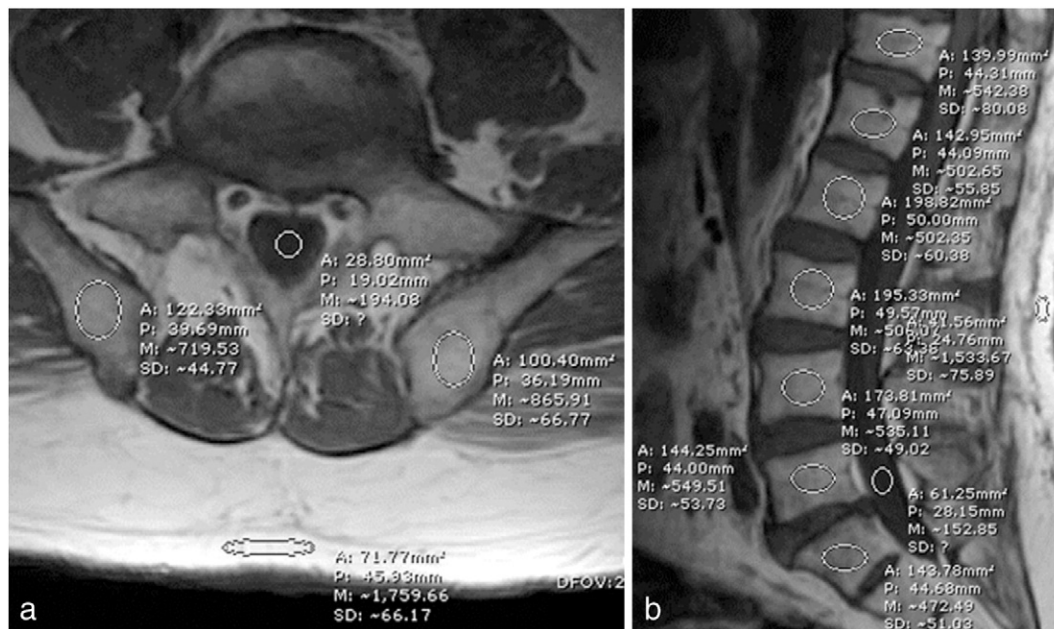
A 56-year-old man with lymphoma without marrow involvement. Axial T1W MR image at the L5/S1 level (a) and midsagittal T1W MR image (b) demonstrate placement of ROI for CSF in the thecal sac, subcutaneous fat, and at each marrow level (right and left iliac bones on the axial image and T12 through S1 vertebral levels on the sagittal image) with corresponding mean SI measurements (M). The ROI area (A), path length (P), and standard deviation (SD) measurements were not used for the calculation of cellularity (%) = $100 - \left\{ \left[\frac{(\text{marrow} - \text{CSF})}{(\text{subcutaneous fat} - \text{CSF})} \right] \times 100 \right\}$.
